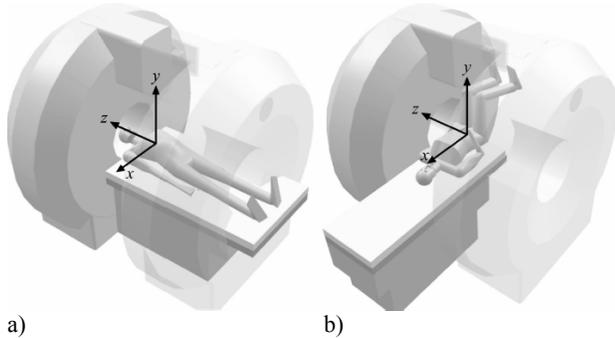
Two positions of the patient in open MRI
